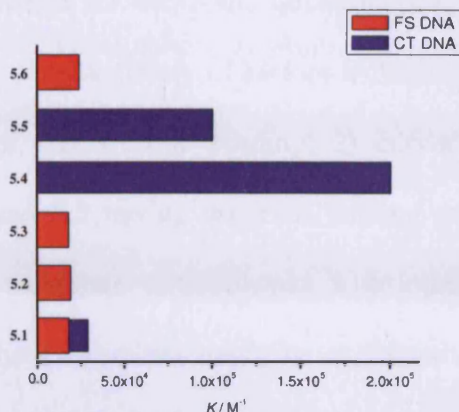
Binding constants by UV-Vis titration for ligands 5.1-5.6 with FS DNA (—) and CT DNA (—) in buffer (25 mM MOPS, 50 mM NaCl and 1 mM EDTA, pH 7.0) at 25 °C.
